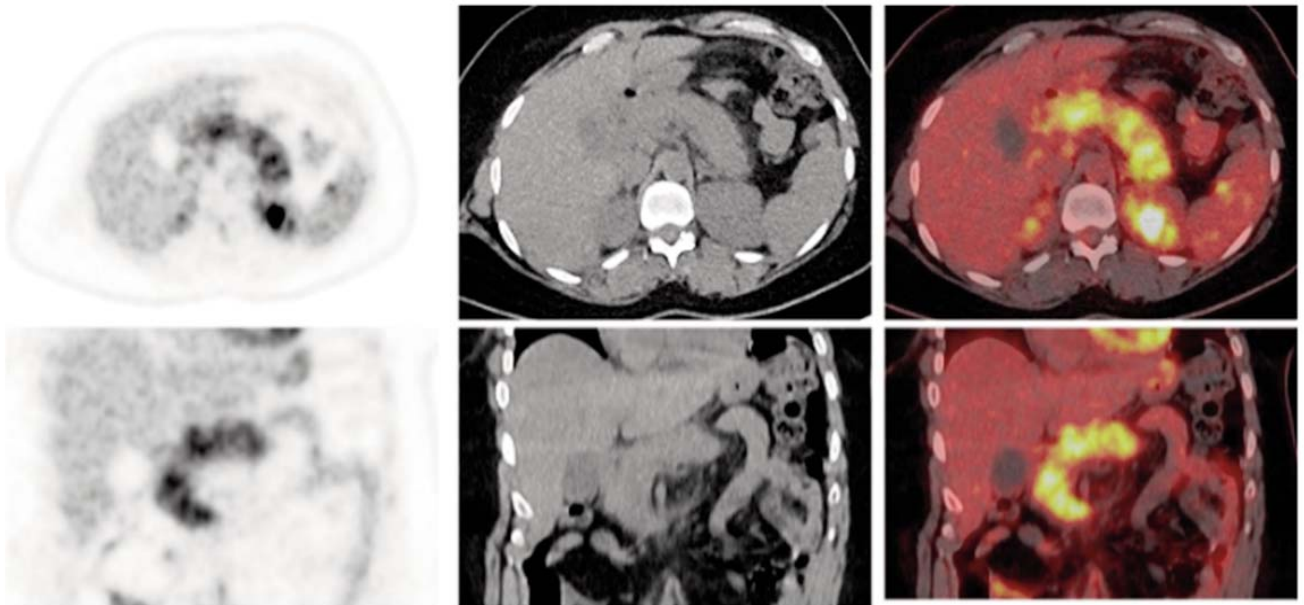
¹⁸F-FDG PET/CT axial and coronal images demonstrate diffuse increased FDG uptake throughout the body of the pancreas associated with fat stranding in the peripancreatic region. Findings are suggestive of pembrolizumab-induced pancreatitis. The diagnosis was confirmed by elevated amylase and lipase levels.
